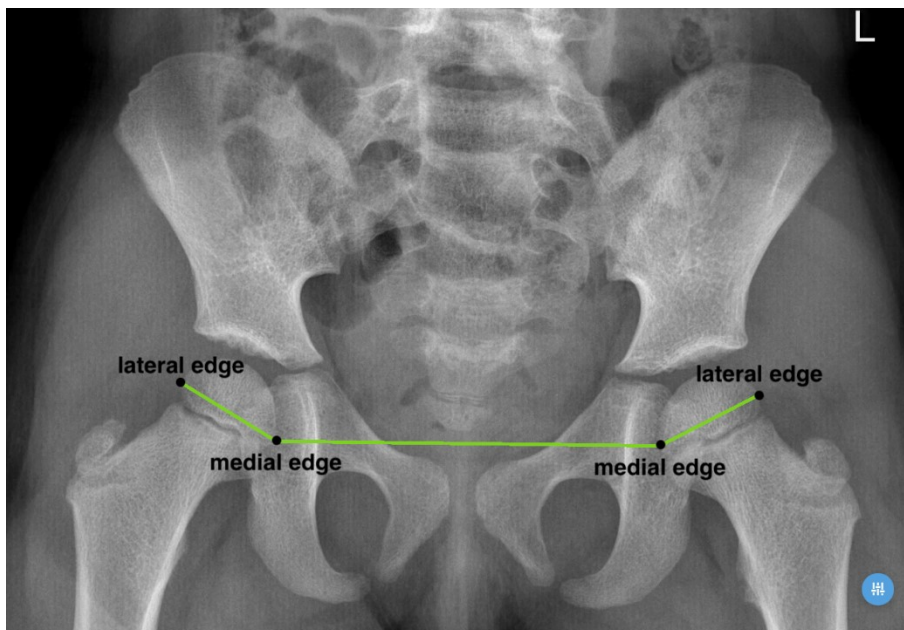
Identification of the MI in the radiograph
